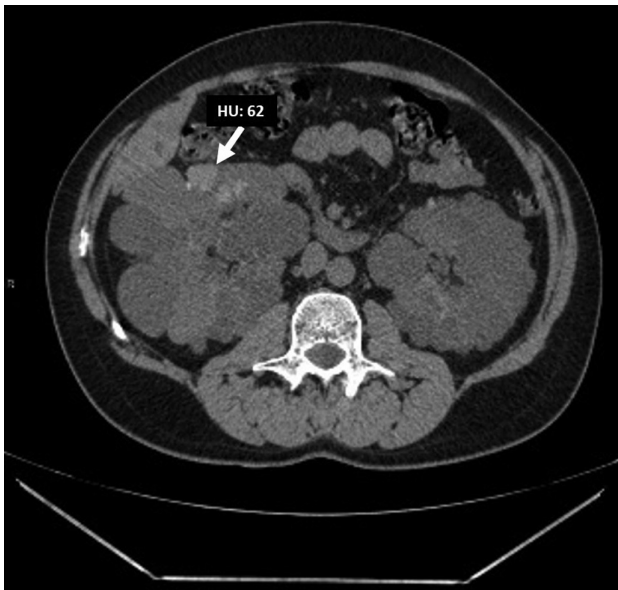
High-density, well-circumscribed hemorrhagic cyst (arrow) is seen on non-contrast computed tomography in an adult patient with polycystic kidney. HU, Hounsfield unit.
